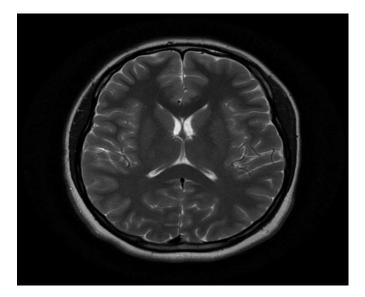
Magnetic Resonance Image of brain [26].
